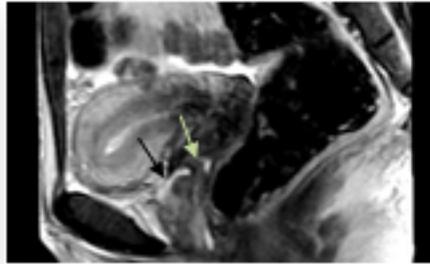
Sagittal MR image of the same patient showing a very small capacity bladder (black arrow) with a thin communication between the vagina and bladder (white arrow) s/o a vesicovaginal fistula. The patient had a complaint of urinary incontinence.
